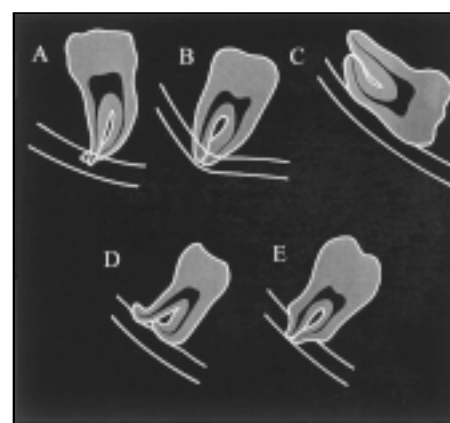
Five radiographic signs suggesting juxtapposition of the mandibular canal to the third molar roots, as described by Rood and Shehab 1990.⁵ Signs significantly related to nerve injury: A. Radiolucency across the roots of the third molar; B. Deviation of the mandibular canal; C. Interruption of the white line of the canal. Signs considered to be clinically important: D. Deflection of the third molar roots by the canal; E. Narrowing of the third molar root.
